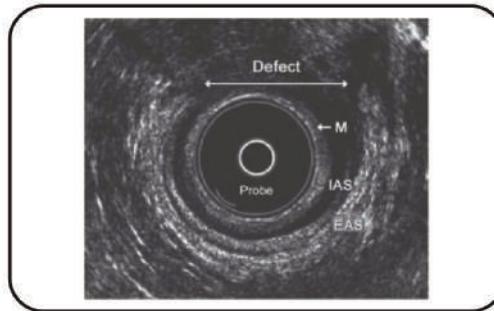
Trans Rectal sonography showing torn anal sphincter from 11 o'clock to 2 o'clock position
